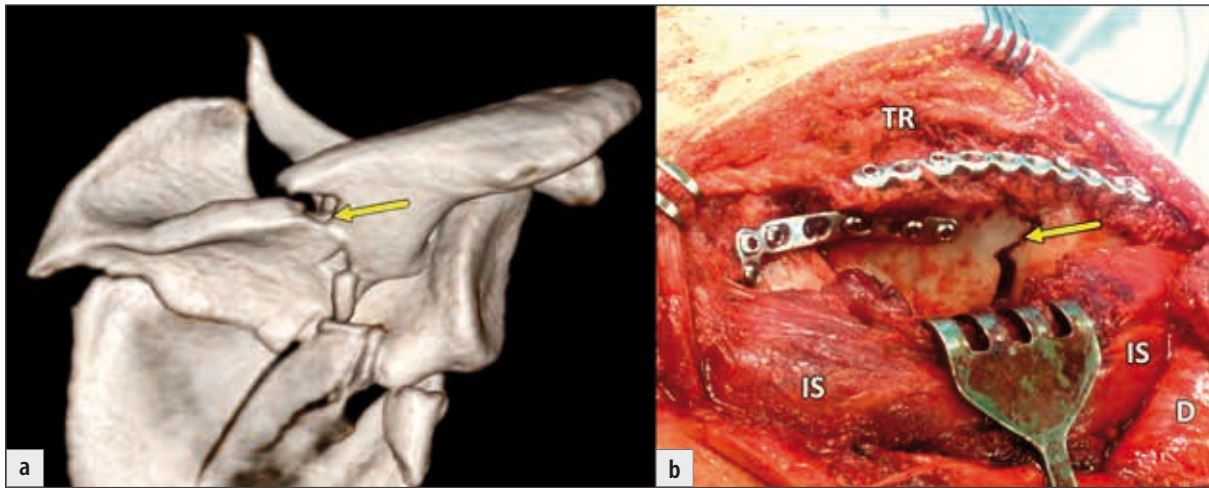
Reconstruction of the scapular spine (spinal pillar): a) 3D CT reconstruction of the fracture from the posterior view; b) reduction and internal fixation with two plates. D – deltoid, IS – infraspinatus, TR – trapezius. Yellow arrow – the fracture line passing through the central weakened part of the scapular spine.
